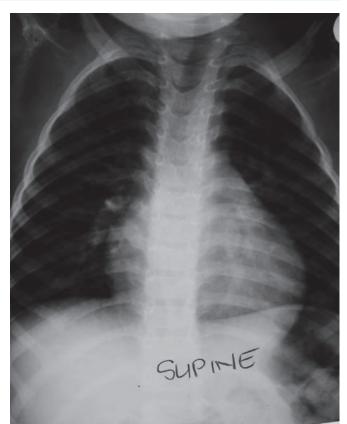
Anteroposterior thoracic radiograph, demonstrating the 13 vertebral bodies, all with ribs attached.
